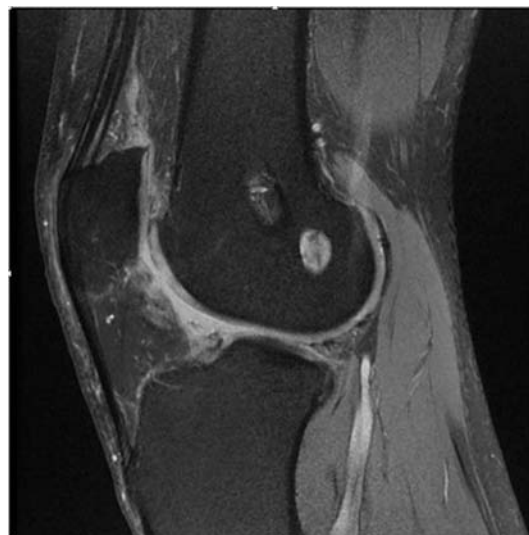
Sagittal MRI of the knee demonstrating anterior placement of the original graft and the posterior placement of the augmentation graft.
